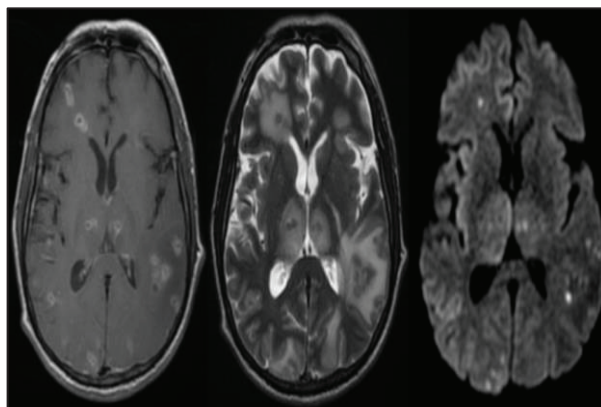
MRI Scan Brain (left image: T1/FSE sequence, center image: T2 sequence, right image: DWI/FLAIR sequence) showing multiple disseminated, rim enhancing lesions with perilesional edema in bilateral cerebral hemispheres, thalami, left basal ganglia, medulla oblongata and cerebellum having no meningeal enhancement
